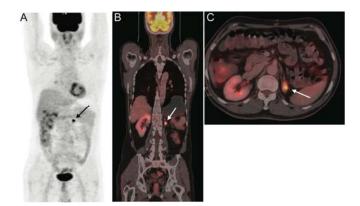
FDG PET/CT images: the maximum intensity projection (MIP) image (A), coronal PET/CT (B) and axial PET/CT (C) show a focus of intense tracer uptake (SUVmax 8.2) in the enlarged left adrenal gland (arrow) as the only site of involvement.
